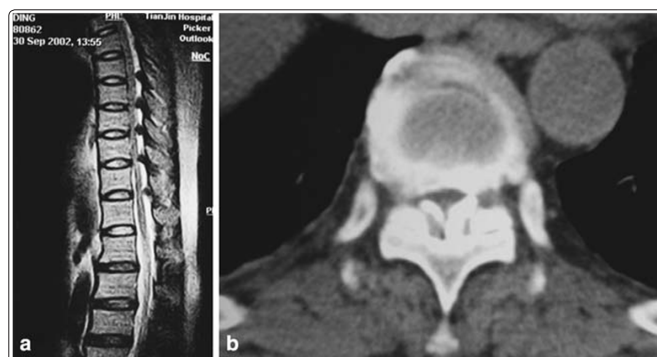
(a) T2 weight MRI of thoracic spine showed continuous multi-level ossification of ligamentum flavum between T7 and T12 (case 5). (b) CT scan showed ossified ligamentum flavum, note that there was a thin gap between the ossified ligament and the lamina
